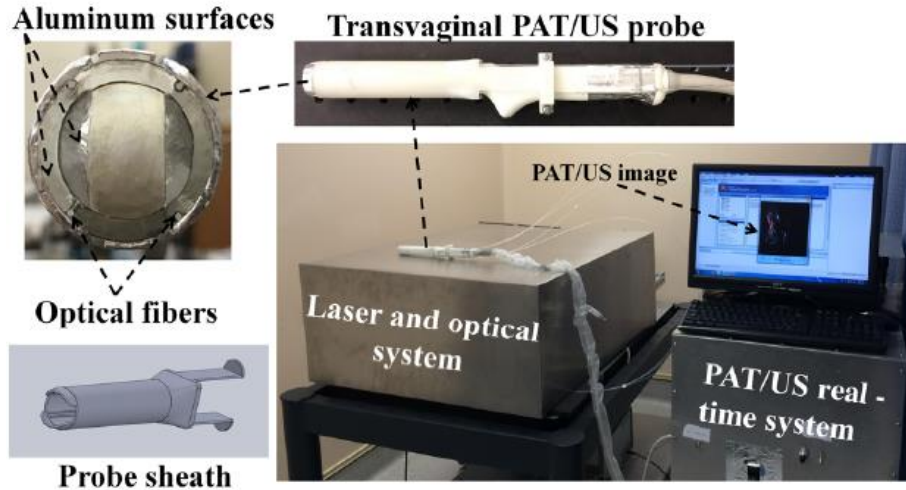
The first generation transvaginal coregistered photoacoustic/ultrasound imaging system located at the Radiology Department of the UCONN Health Center for patients' studies (from Ref. [30]).
